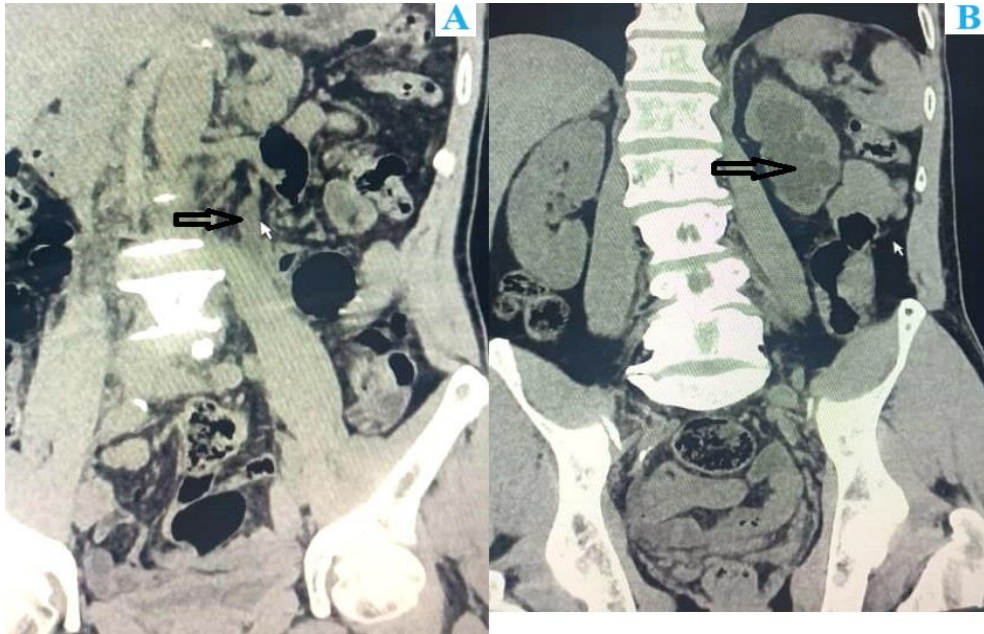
1A: CT image showing a mass in the distal one-third of the ureter (black arrow). 1B: CT image showing hydronephrosis (black arrow)
